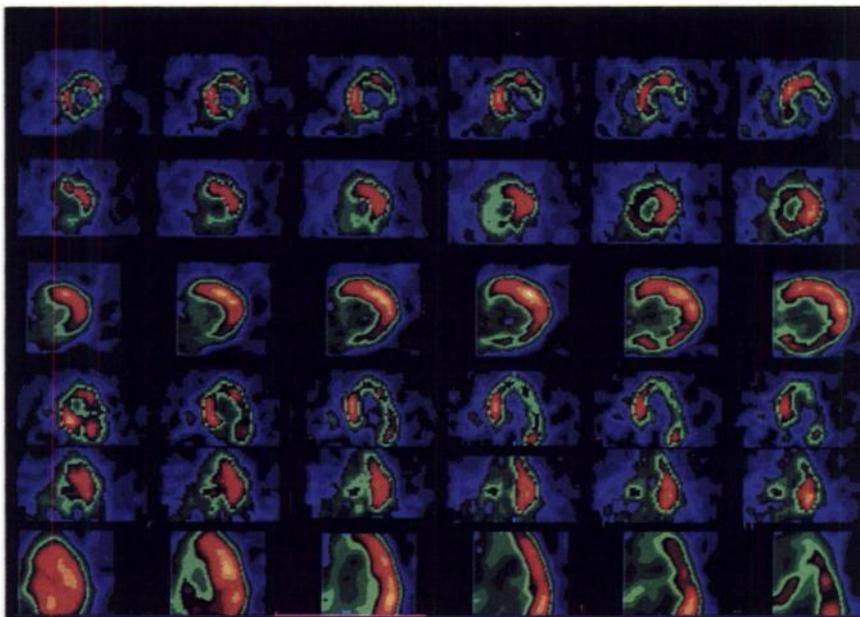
Rest thallium (1st and 4th rows) demonstrates distal lateral and inferior wall fixed defects. FDG-SPECT (2nd and 5th rows) and FDG-PET (3rd and 6th rows) demonstrates hypermetabolism in these segments. Because of the marked increase in FDG uptake the septum appears suppressed. This is a mismatch indicating a severe decrease in perfusion but retained glucose metabolism in the lateral and inferior walls.
